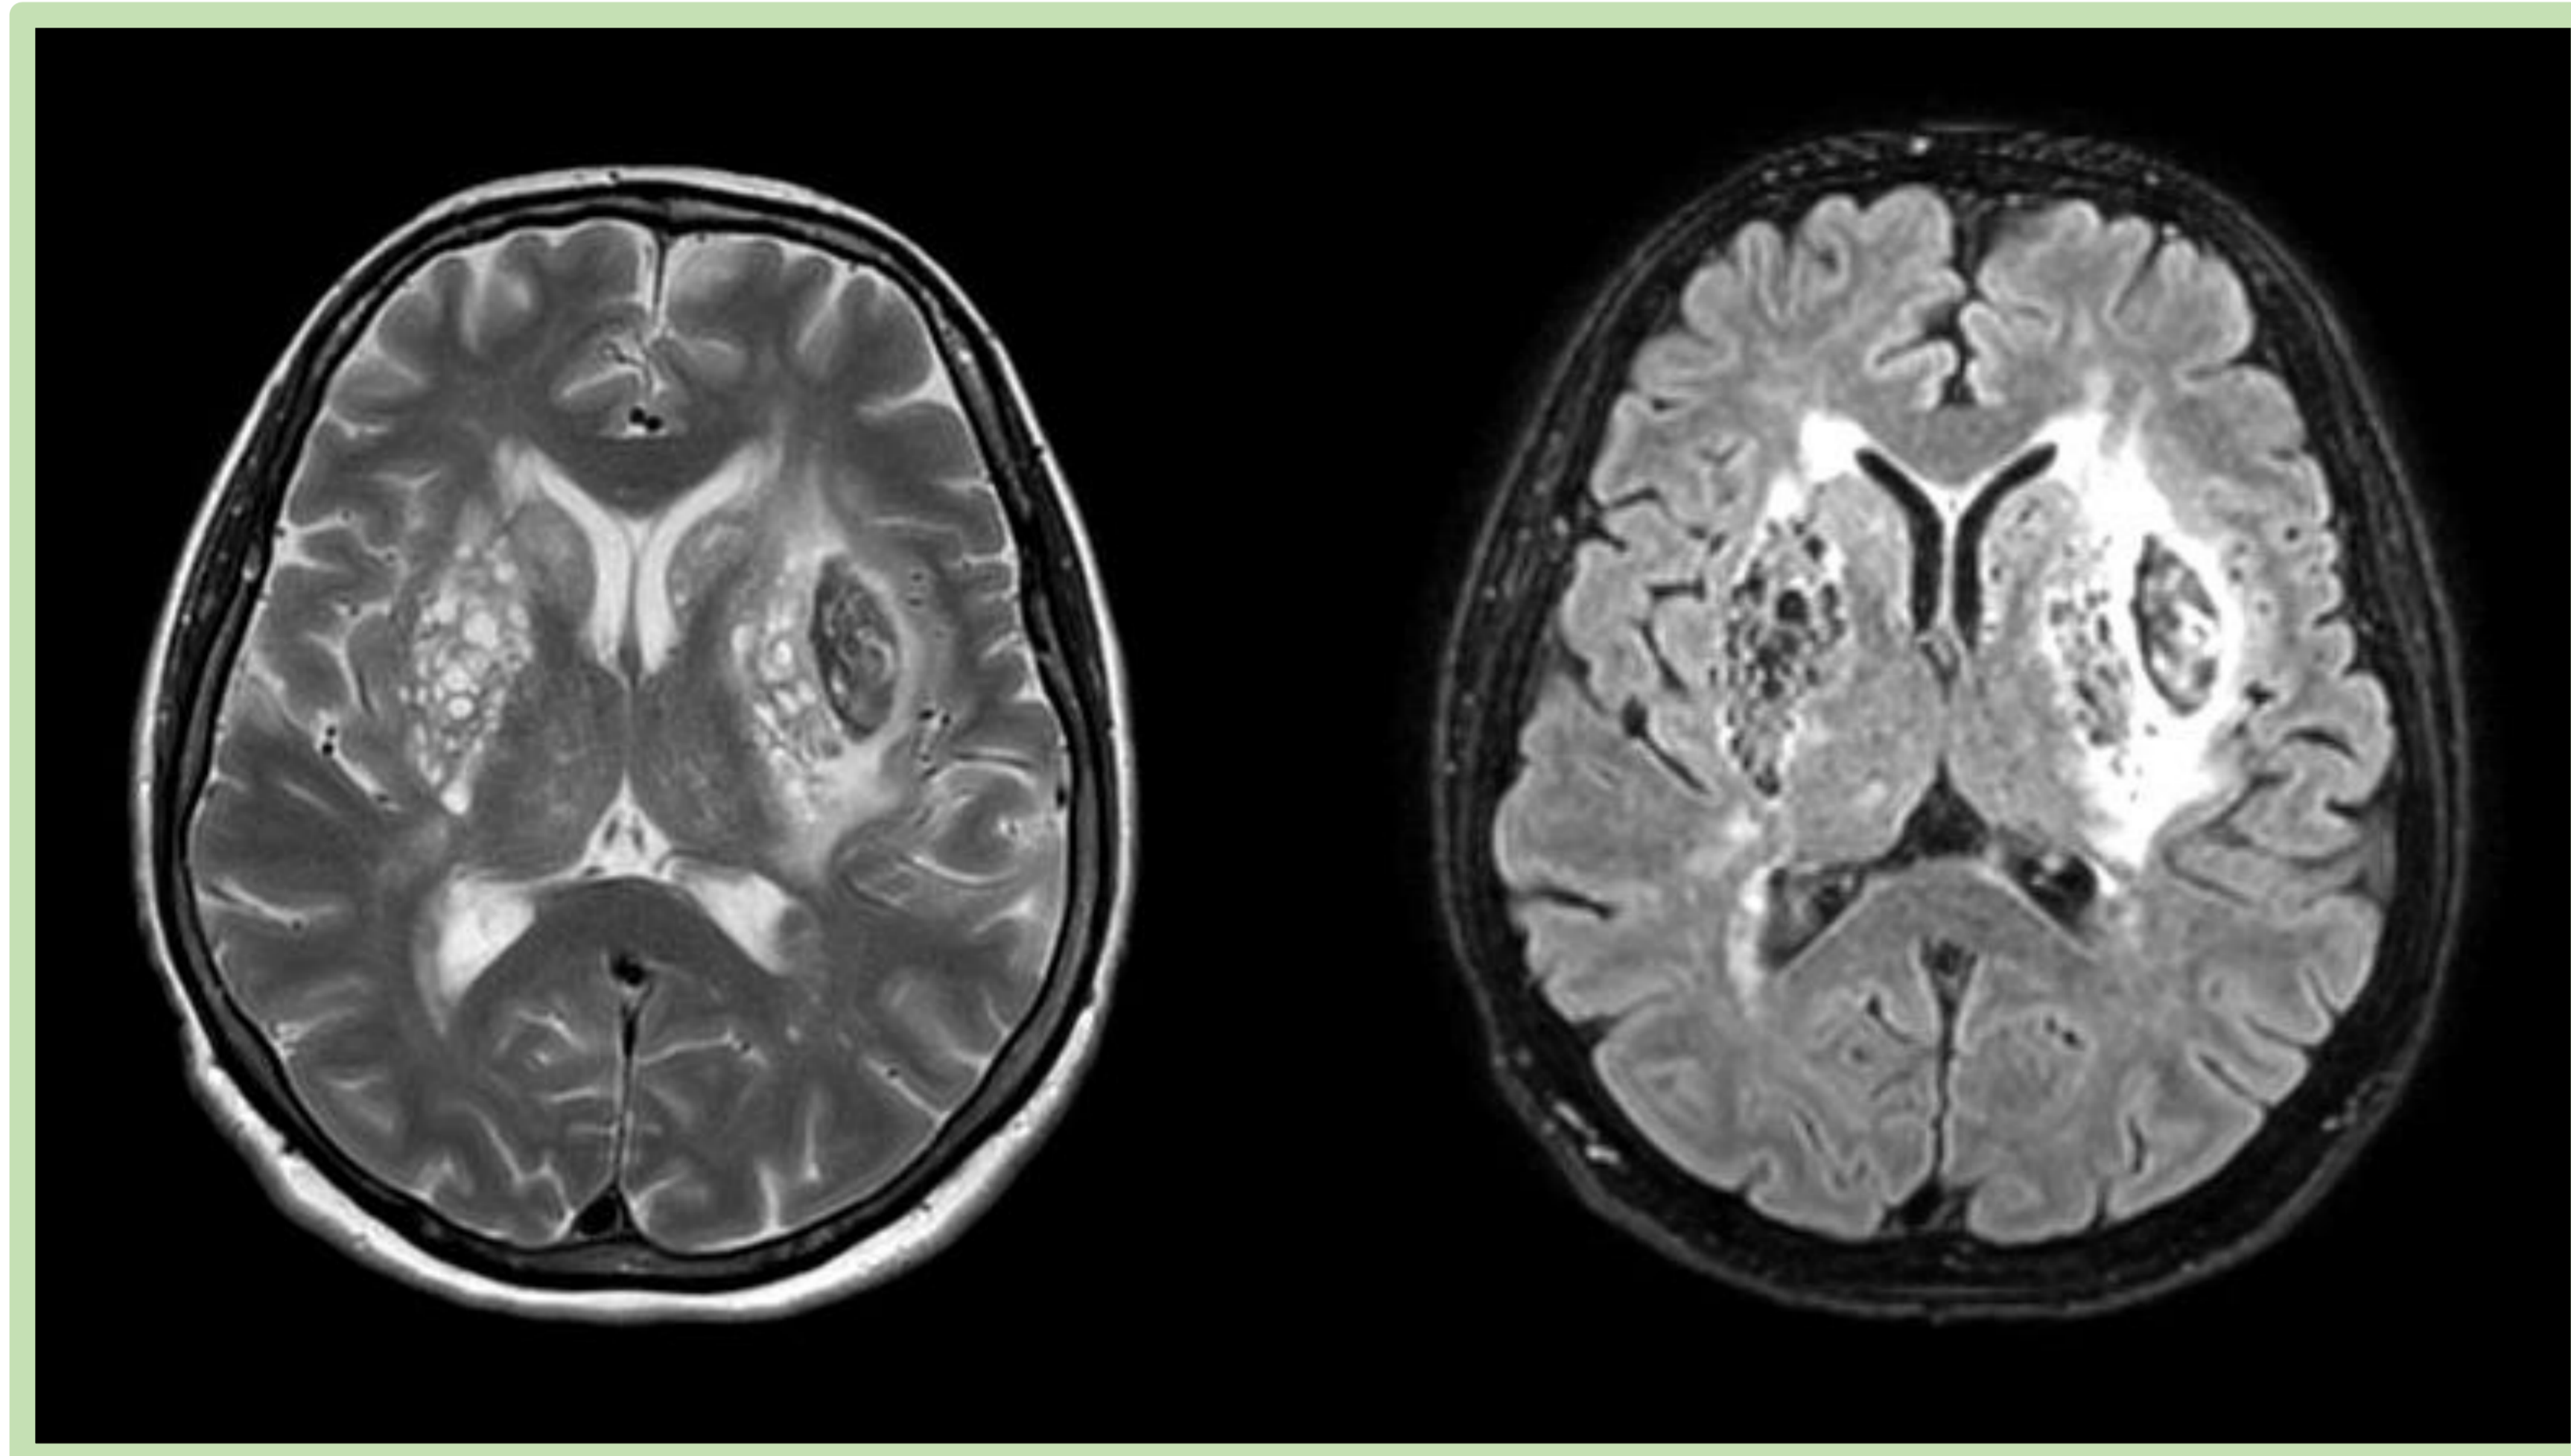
MRI: Multiple T2-hyperintense basal ganglia lesions, presented as hypointense areas on T1-weighted and FLAIR sequences in relation to prominent perivascular spaces.
